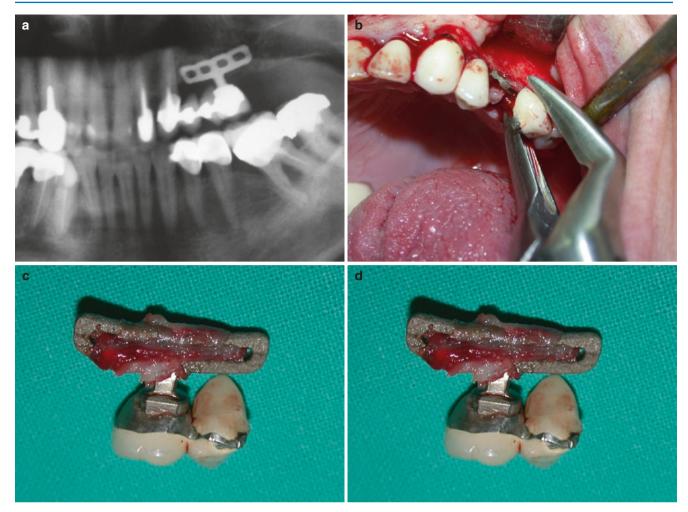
The scalpel-forceps technique and miscellaneous techniques. (a) Preoperative radiographic image of a failing Linkow-type blade implant in the *upper jaw*. (b) The implant-supported crown is grasped with the dental forceps after the fibrous bands around the implants have been severed with a scalpel. (c) The removed implant with the soft tissue capsule around it. (d) Preoperative OPG of a failing "basal osseointegrated implants" in the *lower jaw* (arrow points to the implant that is protruding through the mucosa). (e) The horizontal part of the implant is emerging causing mucositis. (f) The FDP is sectioned and implants removed. Most of implants are bent (arrow) probably to compensate the discrepancy with the mandibular width. (g) The size of the defect that remains following the explantation of the basal osseointegrated implant. The content of the mandibular canal in the region of the left most distant implant. The patient complains of numbness of the lower lip on the left side. (h) The impression copings are mounted on implants after 4 months of placement in the augmented bone. The distal appears to be slightly mobile, and after checking its mobility, the implant is easily unwound together with the impression coping. (i) After the distal implant has been removed, the mesial implant is checked
